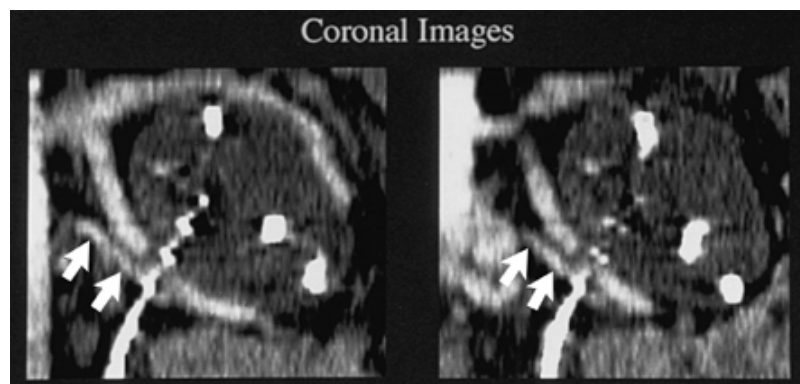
In this spiral computed tomography scan of a 34-year-old male patient with a UPJ obstruction, the coronal reconstruction reveals a vessel (*arrows*) crossing the UPJ posteriorly. The density of the vessel suggests that it is probably an artery.
